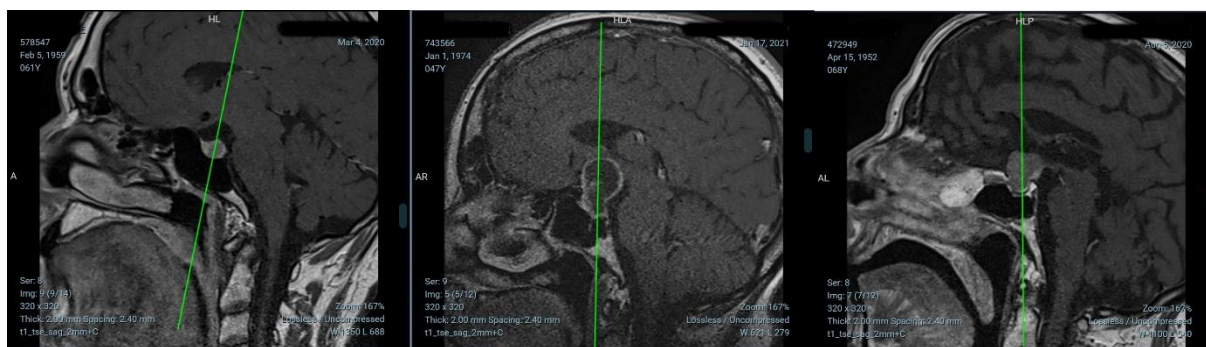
Preoperative MRI of patients
